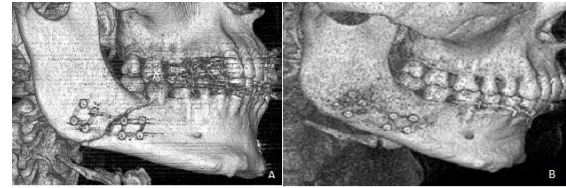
Postoperative CT scans. A: Immediate postoperative , B: 12 weeks postoperative
